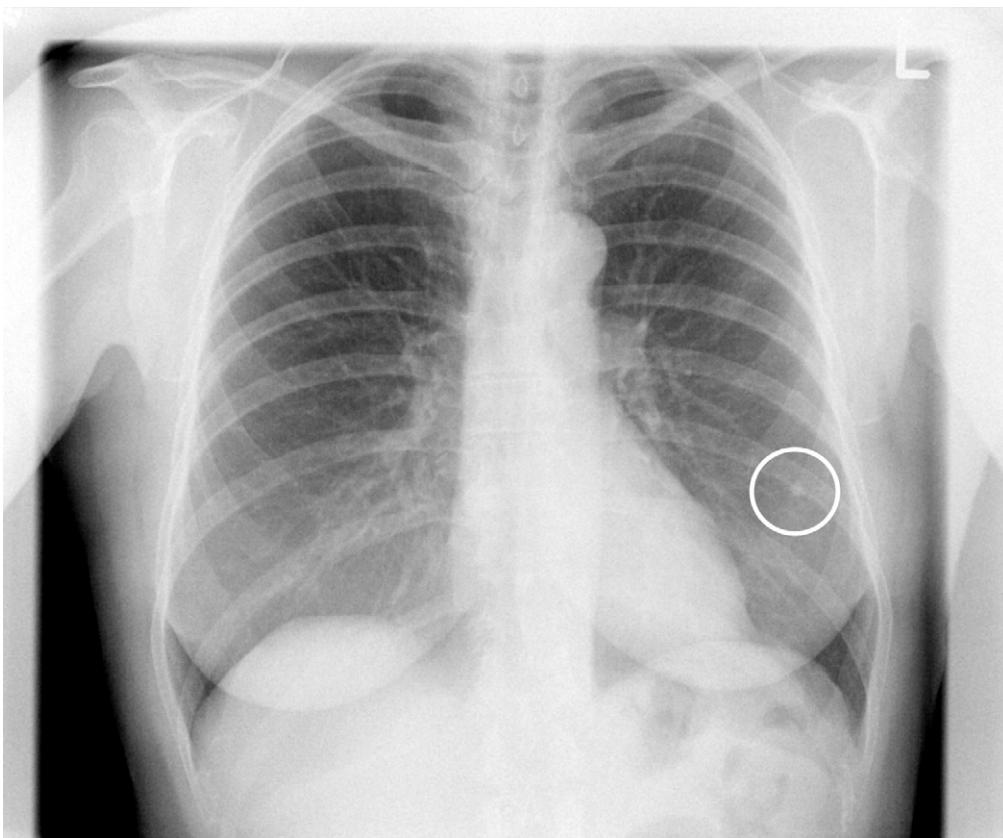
Chest radiograph showing a lung granuloma of 5 mm in diameter (white circle) that had remained unchanged for 7 years in a location atypical for tuberculosis.
